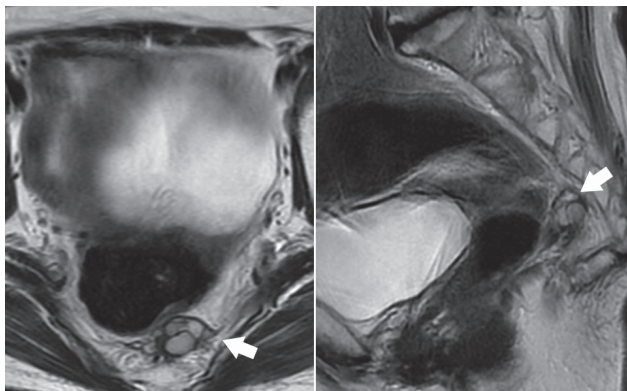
Magnetic resonance imaging showing a presacral multicystic lesion. The lesion shows high signal intensity on T2-weighted images (arrow).
